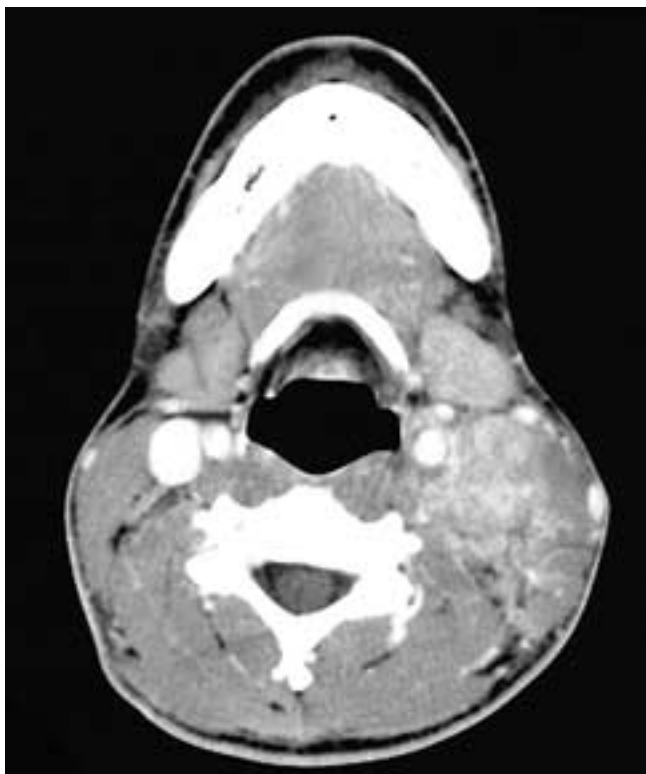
Axial contrast-enhanced CT scan shows multiple variably enhancing left level II and level V lymph nodes with some effacement of the immediate nodal fat planes in this patient with tuberculosis.
